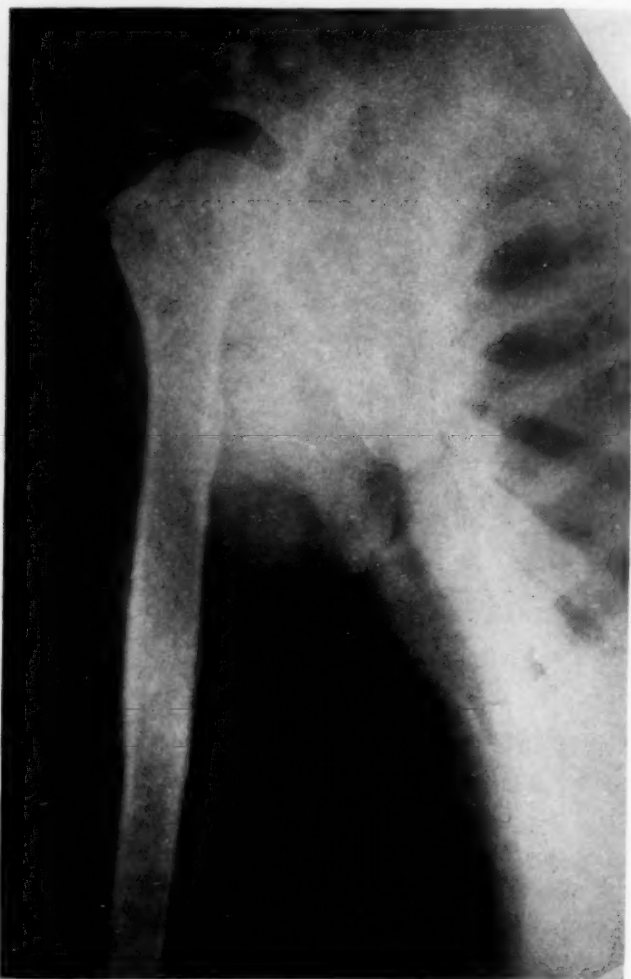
Roentgen-ray of the humerus shows osteoporotic changes and cyst formations similar to those seen in all the long bones. The ribs show diffuse lamellation and irregularity in outline due to disappearance of cortical bone and increase in cancellated tissue.
